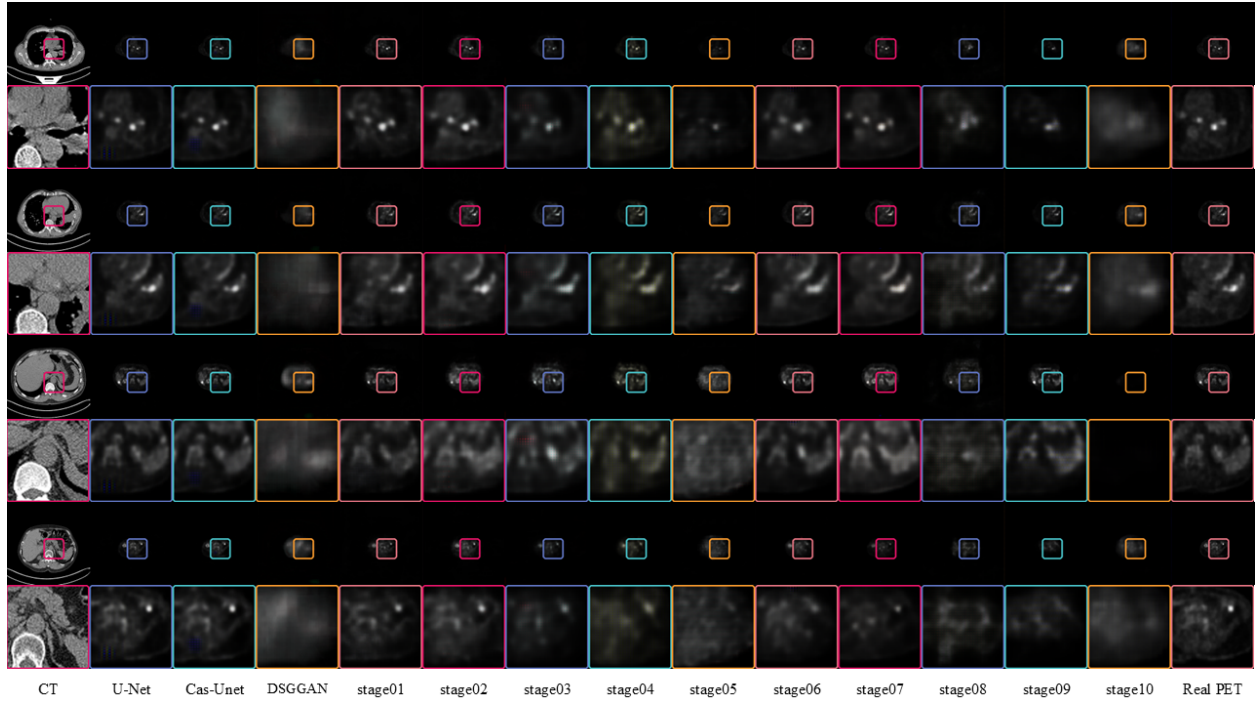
The figure displayed here showcases PET images generated by various models, compared alongside real CT and PET images. The odd rows present the complete paired PET-CT images, while the even rows provide magnified views of specific regions within these pairs. Each model utilizes the CT image located at the extreme left as the input. The real PET images positioned at the extreme right serve as references for comparison.
